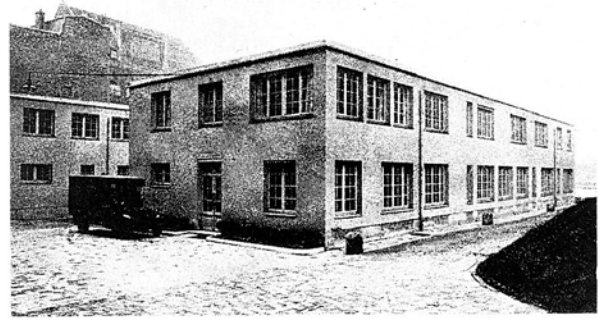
First clinical facilities of the Radium Institute. The structure in front was dedicated to the outpatient clinics, administration, and laboratories; the one in back was devoted to the department of roentgentherapy and to radiodiagnostic facilities.
